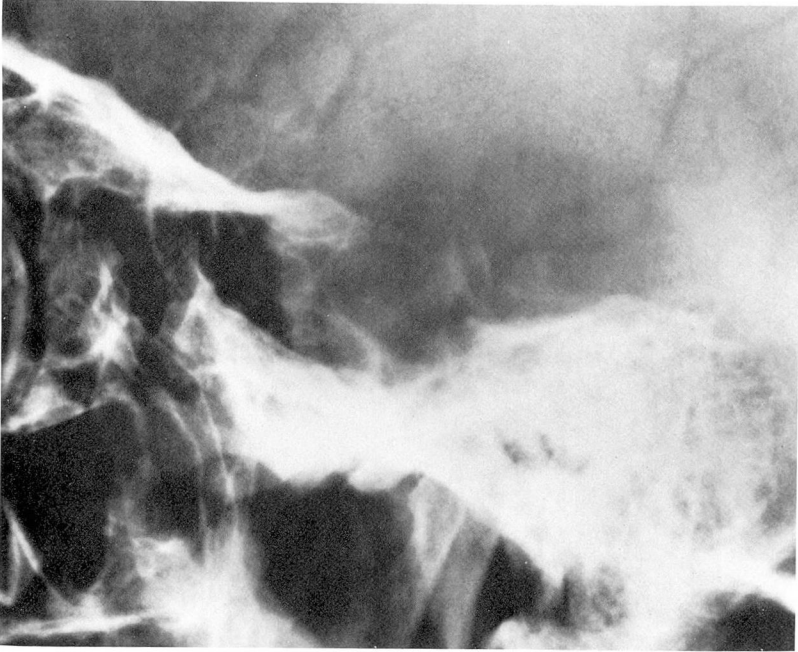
Lateral skull roentgenogram showing enlarged sella turcica with erosion of dorsum.
